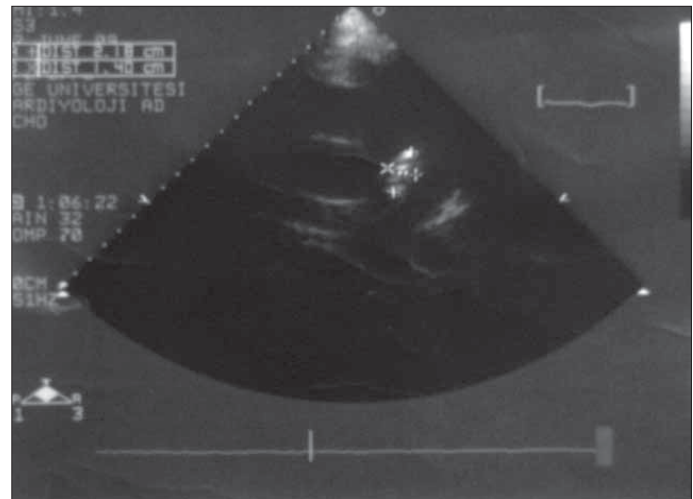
Thrombus in echocardiography was seen as echogenic focus
